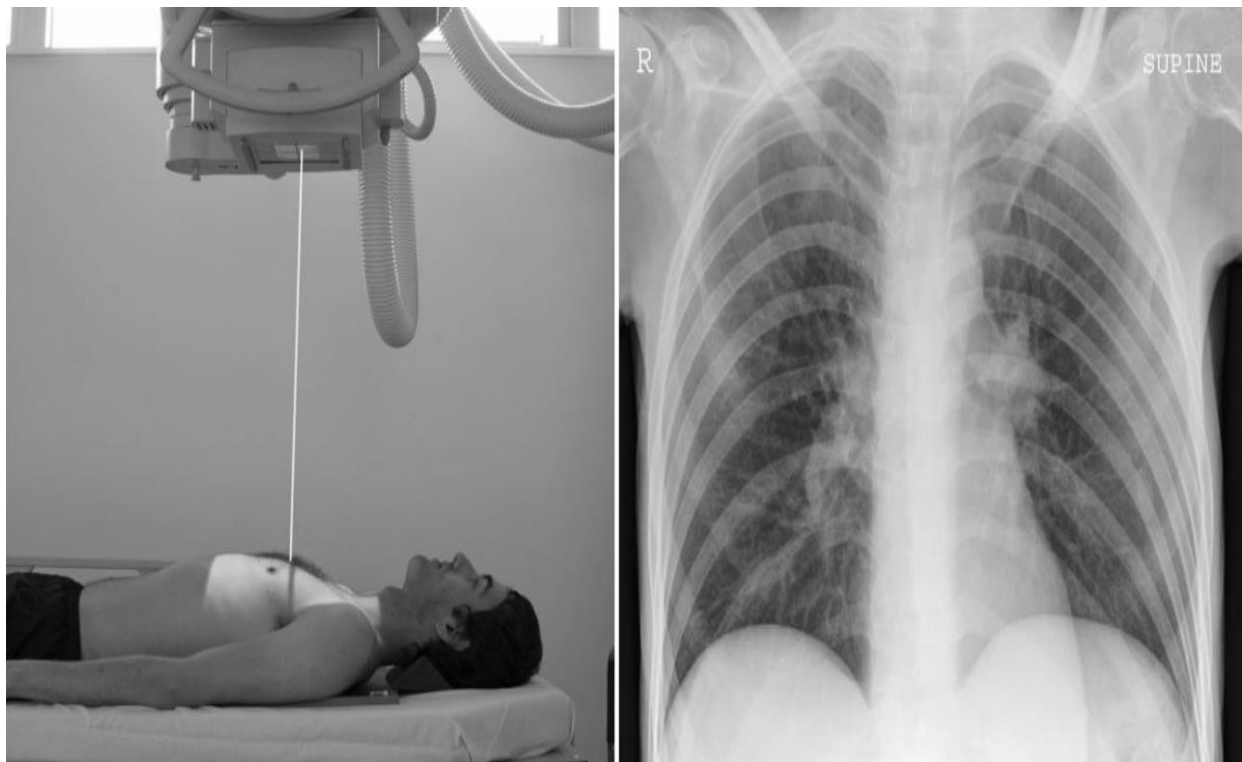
Normal supine radiograph of thorax.
